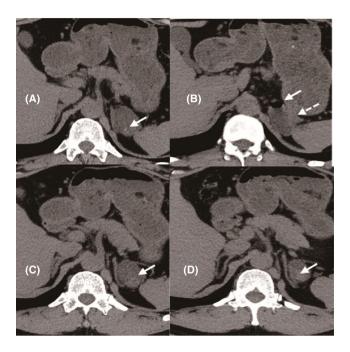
Preoperative repeat CT scan (A) medium highdensity adrenal mass that became larger than Fig. 1A; (B) the solid arrow represents a bubble in the adrenal occupation and the dashed arrow indicates that the occupying position seems to be continuous with the posterior gastric wall; (C, D) mixed-density shadow in the left adrenal region that the shape and location of which had changed.
